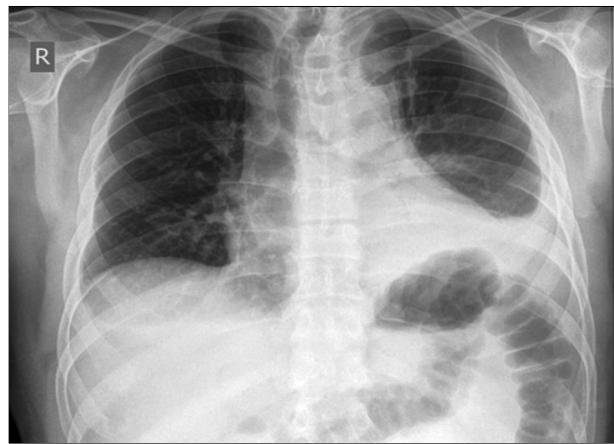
Postoperative chest radiography after drain removal
